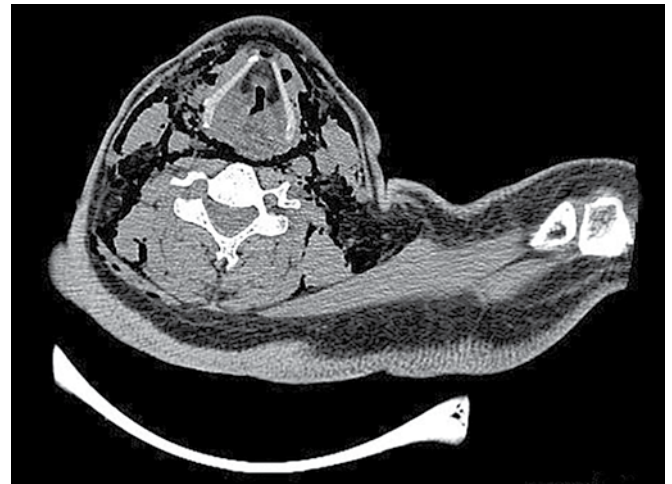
Contrast CT scan axial section showing laryngeal edema
